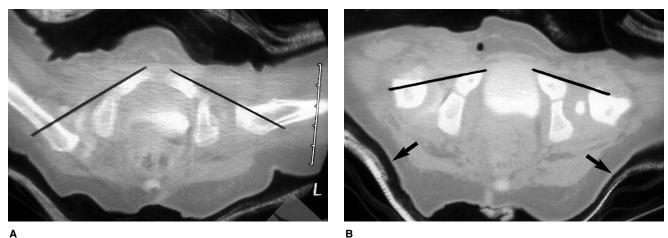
A, CT scan obtained after attempted closed reduction of a dislocated right hip. Line drawn parallel to the right pubic ramus misses the proximal metaphysis. The hip was not reduced, and the patient was immediately taken back to the operating room. B, CT scan obtained after open reduction. Note concentric reduction and well-molded cast (arrows). The small amount of posterior "sag" of the femoral head is acceptable. Lines drawn along the pubic rami are now continuous with the proximal metaphyses on both sides.
